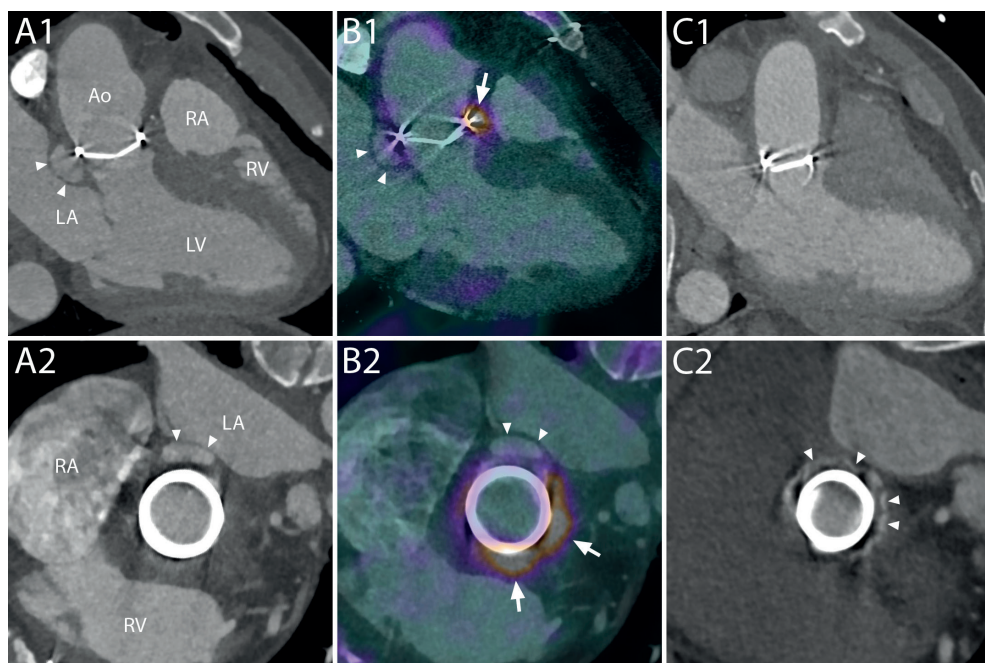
Endocarditis of a mechanical aortic valve prosthesis after Bentall procedure, with an aseptic perivalvular extension on fused ^{18}F -FDG PET-CT Angiography
